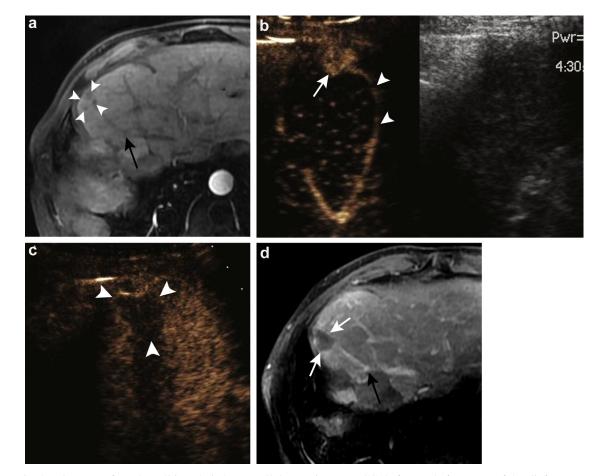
Biopsy-confirmed small isoechoic hepatocellular carcinoma (HCC) before and after successful radiofrequency (RF) ablation in a 64-y-old-man. (a) Contrast-enhanced MRI performed before RF ablation shows an ill-defined heterogeneous iso-enhancing nodule (arrowheads) in liver segment VIII, which presents with multiple small hypo-enhancing areas. (b) A 1.5-cm heterogeneous hyper-enhancing nodule (arrow) is shown on arterial phase contrast-enhanced ultrasound (CEUS) image, whereas this lesion could not be visualized on gray-scale US. One feeding vessel (arrowheads) that enters the lesion's periphery is detected by CEUS. (c) After RF ablation, CEUS image obtained 27 s after contrast agent injection shows no vascularity within the ablation zone (arrowheads). (d) The diagnosis of complete necrosis (arrows) is confirmed by 1-mo post-ablation contrast-enhanced MRI. The same feeding vessel (black arrow) entering the lesion's periphery could also be seen on MRI images (a and d), suggesting that the anatomic location of the index tumor is consistent with the ablation zone.
